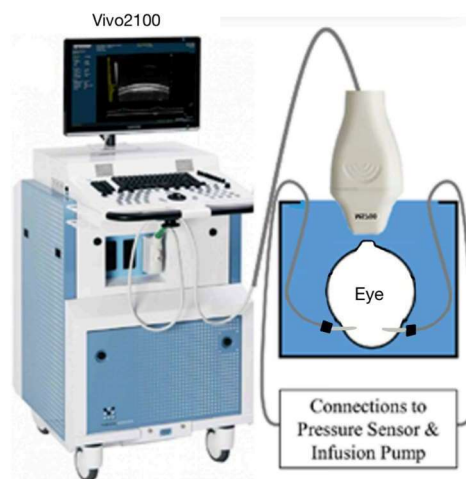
Ultrasound Vivo Imaging System and Setup
